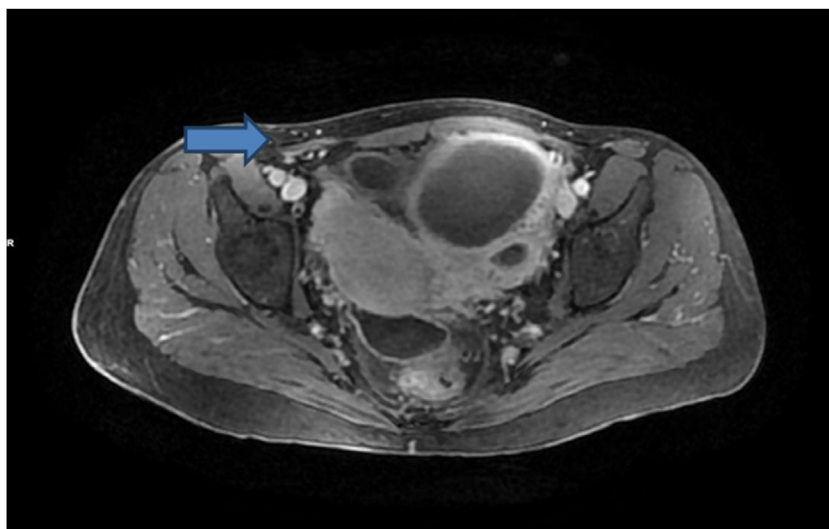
Pelvic MRI showing acute Peritonitis (arrow).
